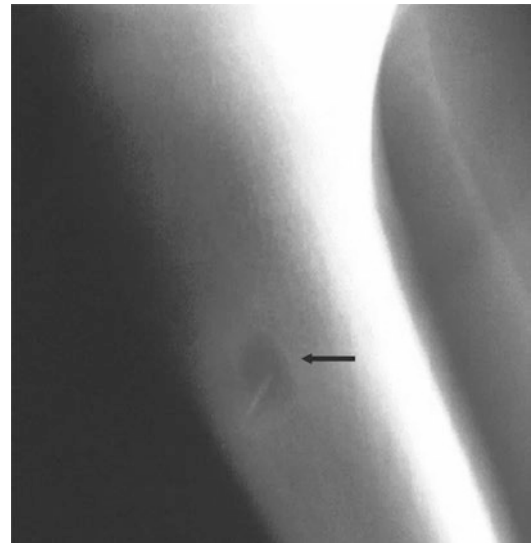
Radiograph showing Brodie's abscess (arrow)
